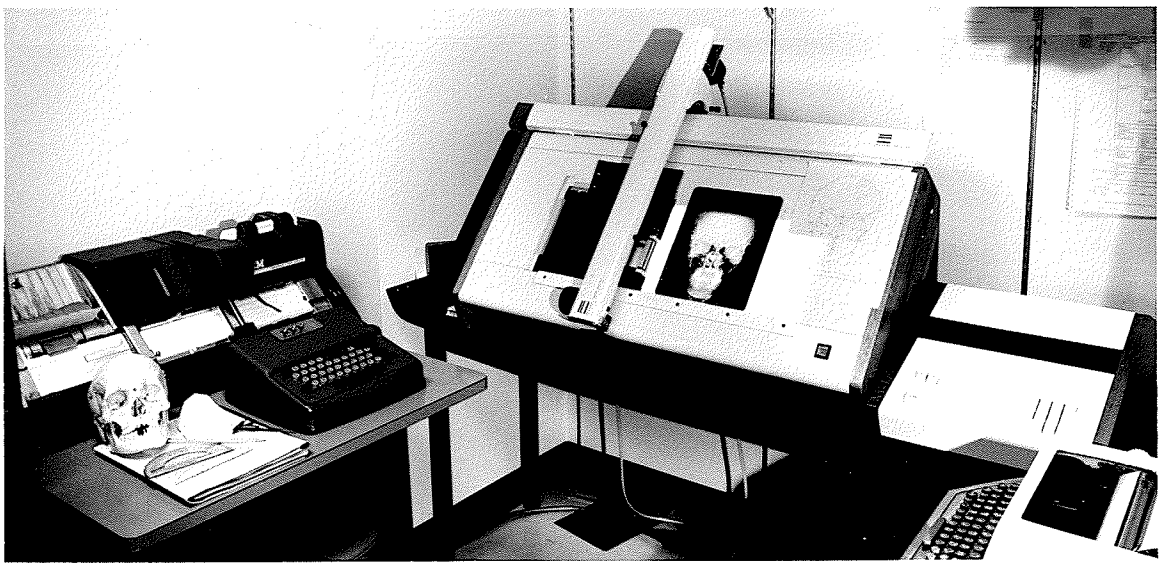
Digitization equipment used to record the coordinates of the landmarks from the P-A cephalometric radiograph
